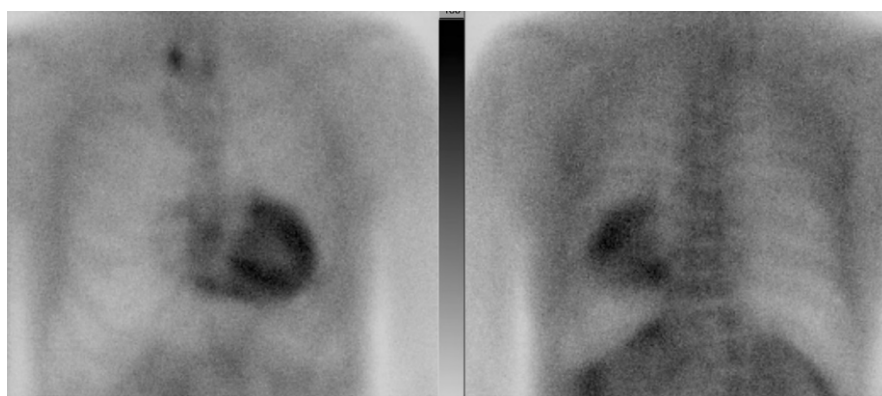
Targeted static scintigrams of the thorax in anterior and posterior projection, with evaluation corresponding to Perugini score 3 and heart/contralateral lung fixation ratio (H/CL ratio) 2.6 two hours after radiopharmaceutical application.
